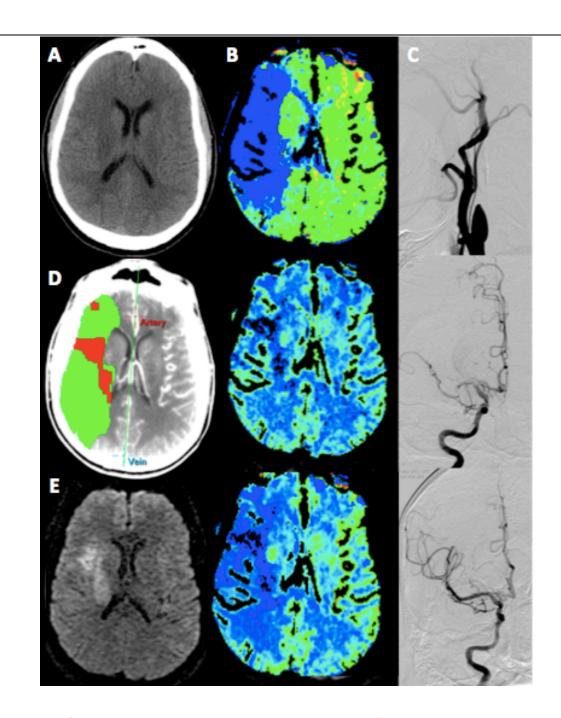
Sample case: 49-year old man presented with left hemiparesis and imaging was performed 1h after symptom onset. A: NCT images show no intracranial hemorrhage B: PCT maps (from top to bottom: MTT, CBV, CBF) show increased MTT and decreased CBV and CBF in the right frontal and temporal lobes. D: The region of decreased CBV corresponds to the infarct core, whereas the surrounding mismatch region of prolonged MTT represents the ischemic penumbra. Patient is treated with IV rtPA followed by mechanical thrombectomy. C: DSA images (from top to bottom) 2h after system onset show occlusion of the right internal carotid artery and of the M1 segment of the right MCA before and after recanalization with Merci retriever system and stent. F: Follow-up DWI scan shows small infarct volume corresponding to the infarct core determined with PCT. Patient shows favorable clinical outcome at discharge and at 90 days.
